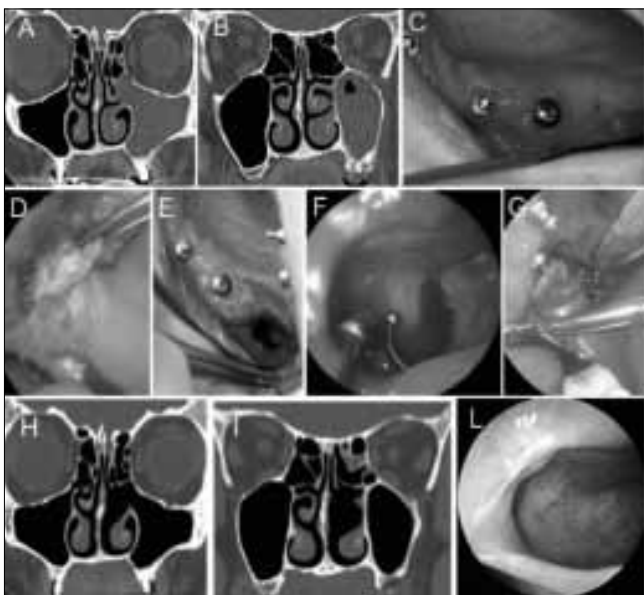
Patient 24. SCDĐT resulting from maxillary sinus lift with OAF (Class 1). Preoperative coronal CT scans showing A) unilateral left maxillary sinusitis and obstruction of the ostiomeatal complex, and B) maxillary osteitis after bone graft in the posterior maxillary alveolar process; C) Preoperative intraoral view: no clinical evidence of infection; D) Intraoral approach with trapezoidal flap, and E) after bone graft removal and bone debridement; F) Intraoperative view showing a probe, inserted through the oroantral communication, visible from maxillary sinusotomy (45° endoscope); G) Buccal fat pad flap preparation, then Rehmann buccal flap was used for pedicled buccal fat pad flap (PBFPF) covering; H, I) Control coronal CT scans, 6 months after surgery showing complete aeration of the maxillary and ethmoid sinuses on the left side as well as removal of the bone graft and its repair; L) Nasal endoscopy showing the maintenance of the maxillary sinusotomy and the absence of mucosal degeneration (45° endoscope).
